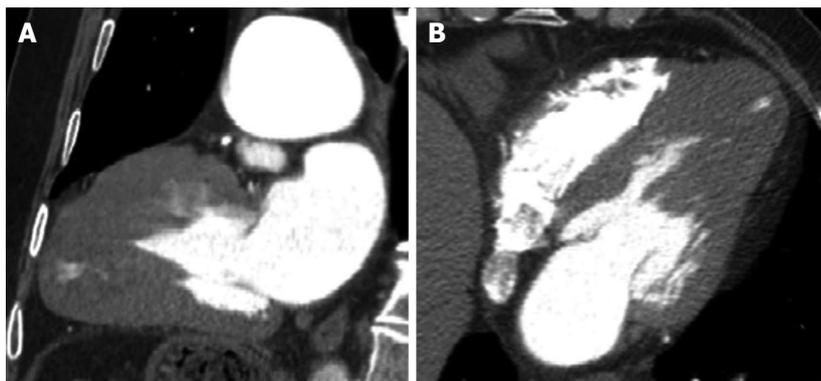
Multidetector computed tomography imaging: Long axis view (A) and axial scans at the level of the left ventricle (B) showing apical hypertrophy with cavity obliteration and a sequestered small left ventricle cavity.
